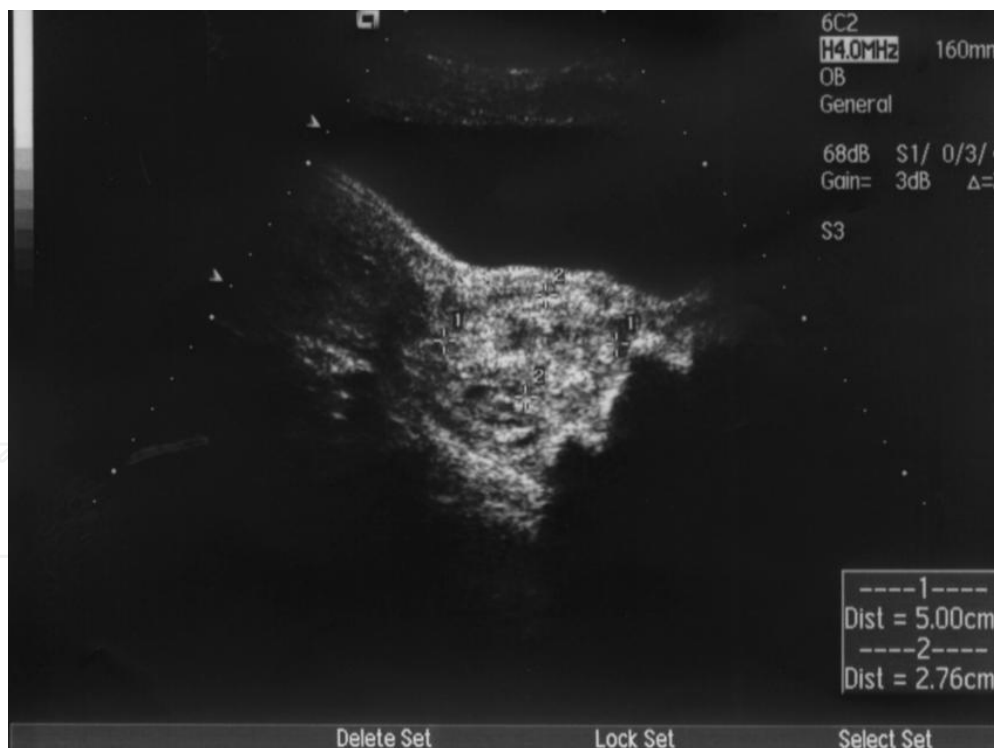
A failure case of cervical pregnancy treated by UAE only. The sonography consistently revealed a heterogeneous mass in the cervix although serious bleeding was successfully controlled by UAE. The patient presented intermittent vaginal bleeding again. The patient underwent second UAE followed by immediate curettage and obtained complete solution. (Xu, et al. J Obstet Gynaecol Res. 2007;33:190-4)
